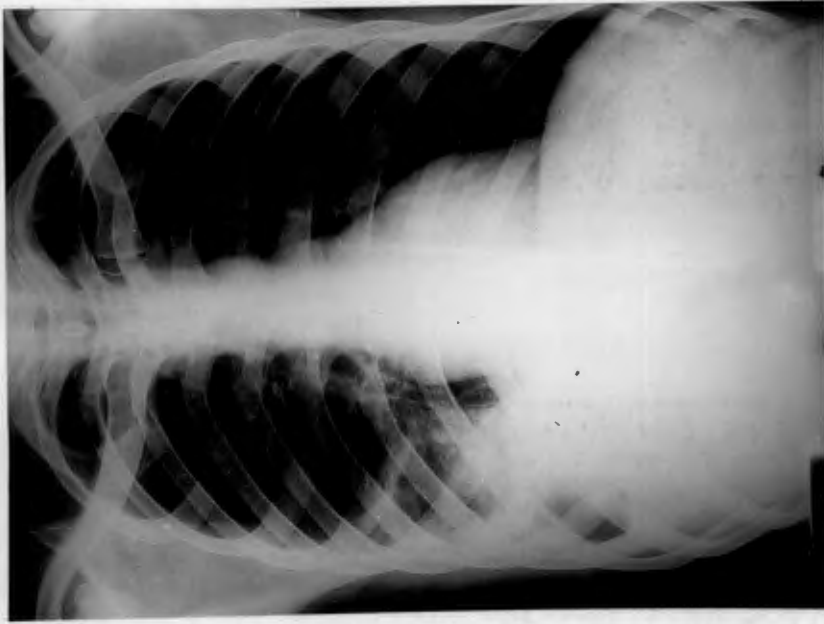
Case 1 Postero-anterior radiographs of the chest of a patient with a hepatobronchial fistula and aneobic lung abscess.
